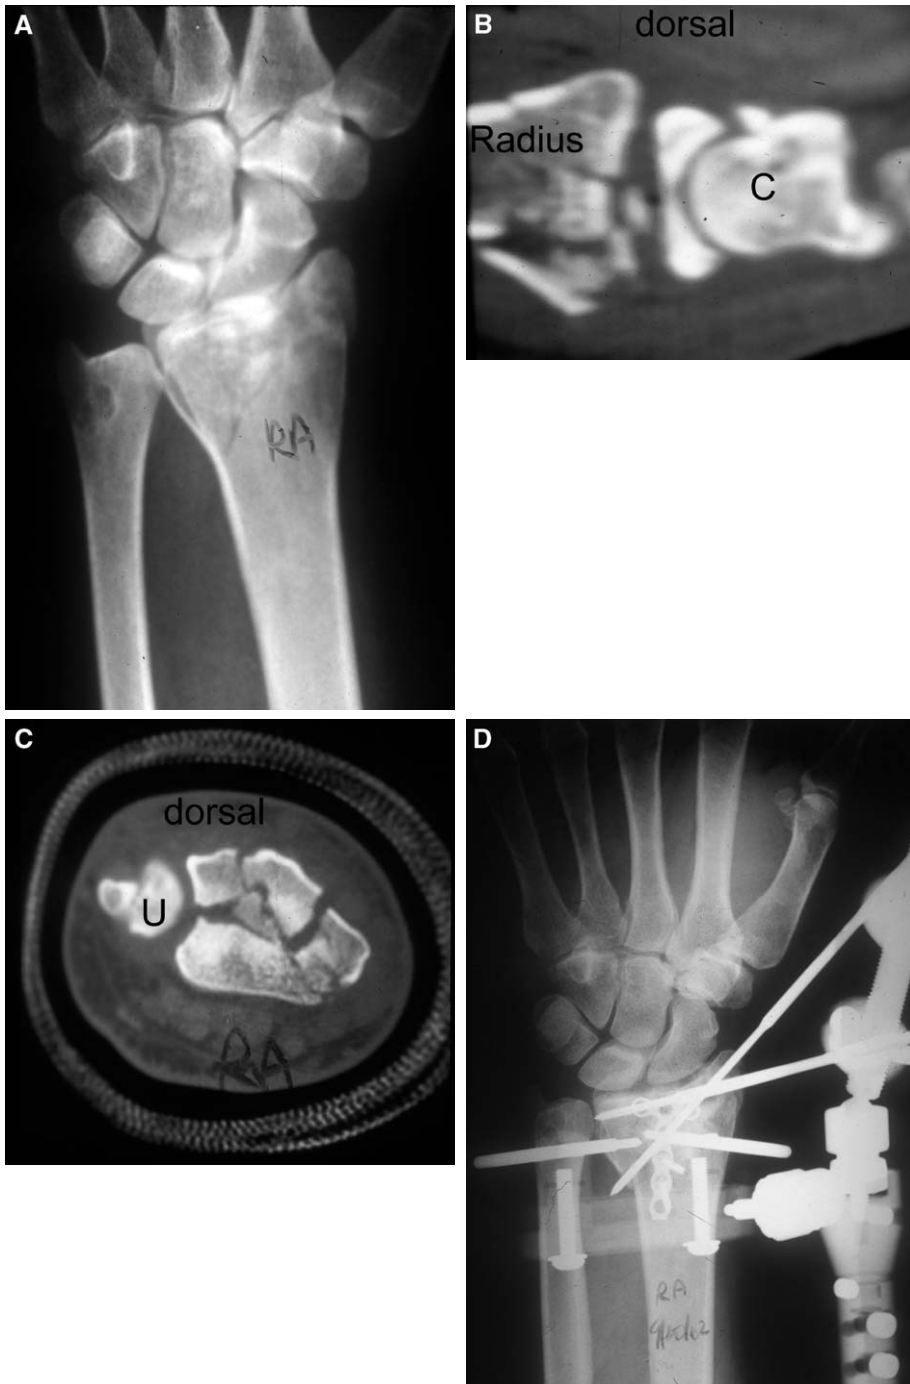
Comminuted intra-articular left distal radius fracture. (A) AP radiographic view of distal radius. (B) Sagittal CT view reveals multiple free articular fragments. C, capitate. (C) Coronal CT view highlighting the central comminution. U, ulna. (D) AP radiographic view demonstrating a congruent joint surface after limited internal fixation, bone grafting, and nonbridging external fixation. (E) Clinical photograph of nonbridging fixator at 6 weeks. (F) Lateral view of fixator.
